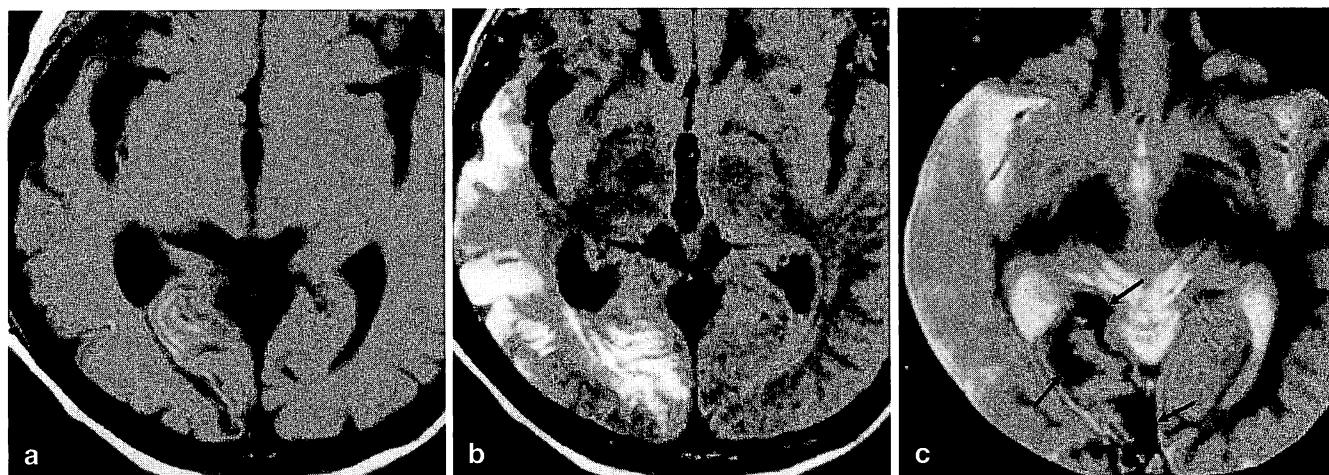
A 53-year-old woman with a right temporo-occipital cardioembolic infarction. These images were obtained at 3 months after ictus. a T1-weighted image shows a high intensity cortical lesion and low intensity subcortical lesion. b FLAIR image shows the high intensity cortical lesion but the subcortical lesion remains iso-intensity. c T2*-weighted gradient echo image shows low intensity haemosiderin (*arrows*), which does not correlate with the cortical lesions with short T1 values
